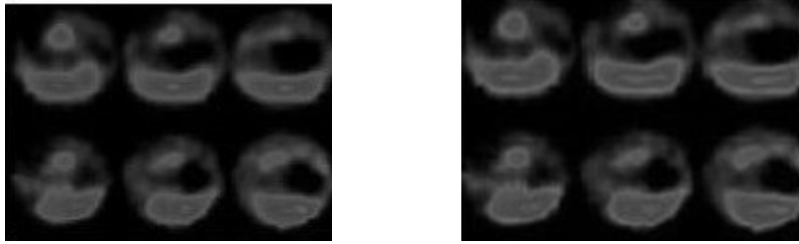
Cardiac SPECT image slices (low tracer content region) and the corresponding enhanced slices using the proposed method
